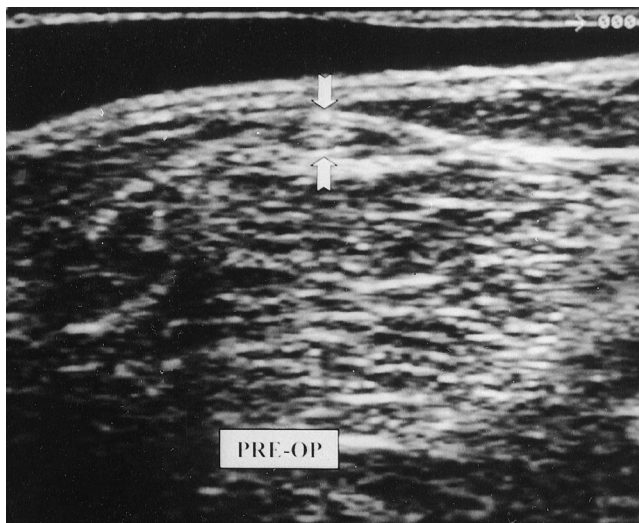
Transverse sonogram of a normal semitendinosus tendon (outlined by arrows).
